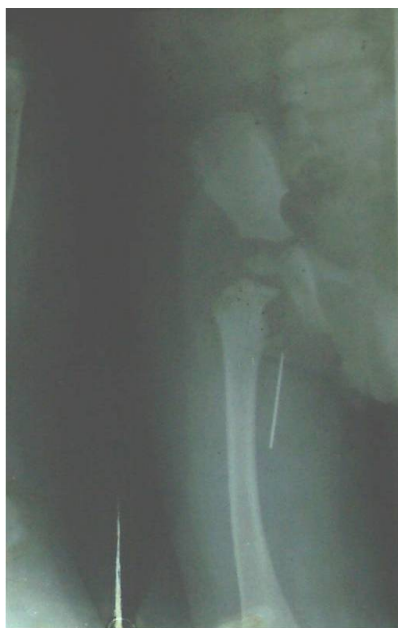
Previous X-ray of case-1, showing needle in thigh.
